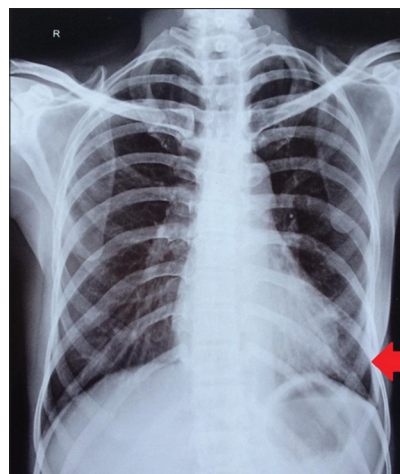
Chest X-ray PA view on admission showing right-sided moderate pleural effusion with hydropneumothorax (red arrow showing air-fluid level)
